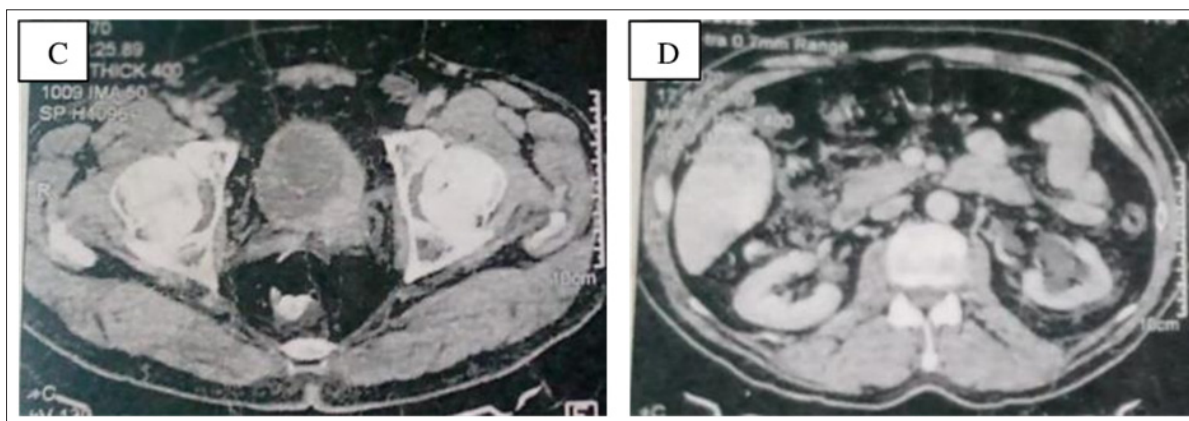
Before chemotherapy: an injected thoraco-abdomino-pelvic CT scan showing a tumor of the left anterolateral wall of the bladder measuring 22.9 x 35.4 mm in size (C) and responsible for a moderate left ureterohydronephrosis (D).
